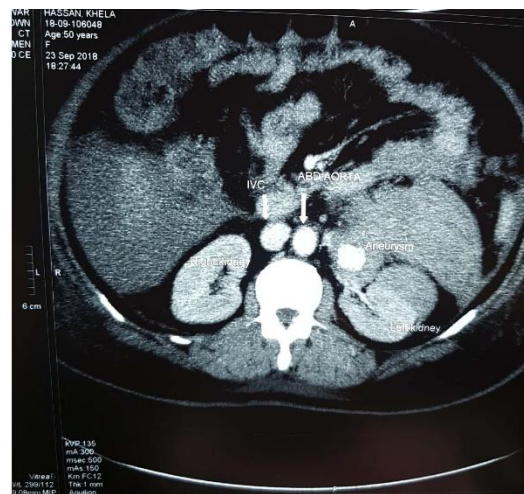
A transverse view of the CT - Scan abdomen shows the presence of the abdominal aorta and the inferior vena cava and the left kidney and the proximity of the aneurysm.
